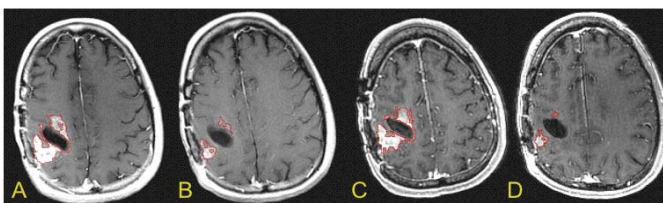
Comparison of Vt and Vh. Post-contrast thick(A-B) and high resolution MRI T1WI(C-D) of 55 years old female with recurrent glioblastoma, 140 days after initiation of anti-angiogenic therapy(A, C) and 35 days later(B, D). The Vt has decreased to 44% of its original size, and would be classified as stable disease; but Vh has decreased to 25%, and would be classified as a partial response.
